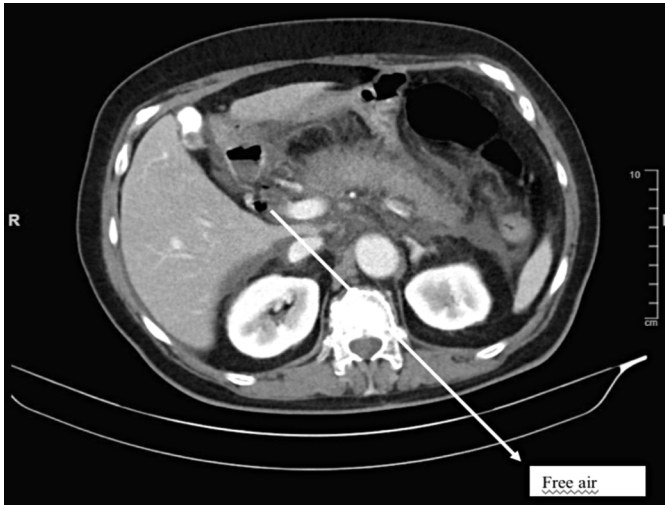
Free air around the duodenum on the oral IV contrast-enhanced abdominopelvic CT, obtained after the perforation diagnosis following the abdominal pain complaints of the post-ERCP patient.
